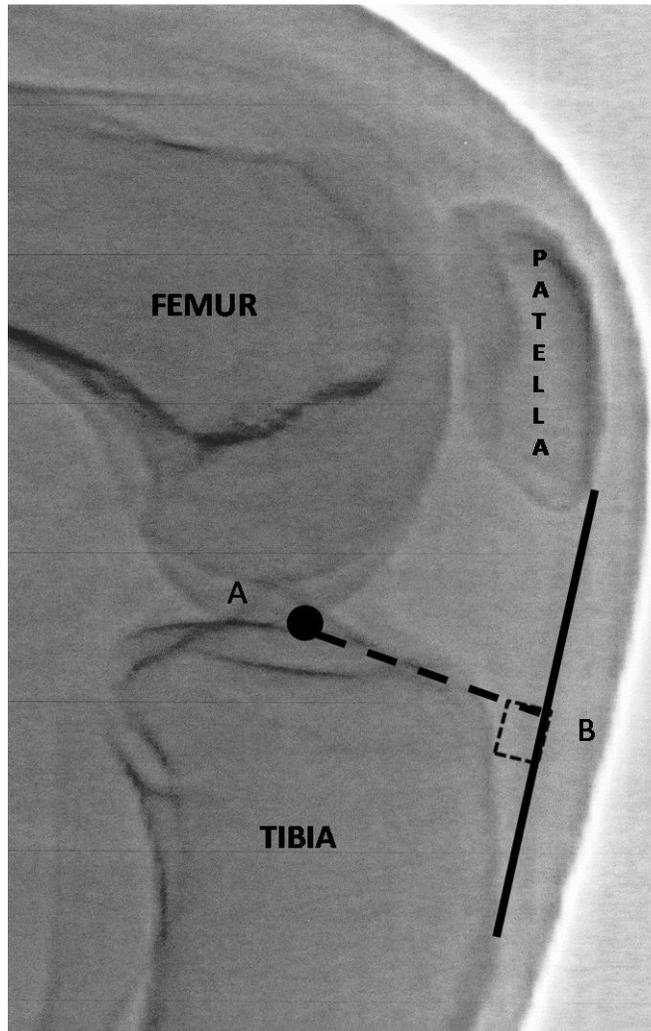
Shows a typical sagittal plane image taken by Dual Energy X-ray Absorptiometry (DEXA) with the knee at 90° flexion for measurement of patella tendon moment arm (Line A-B).
